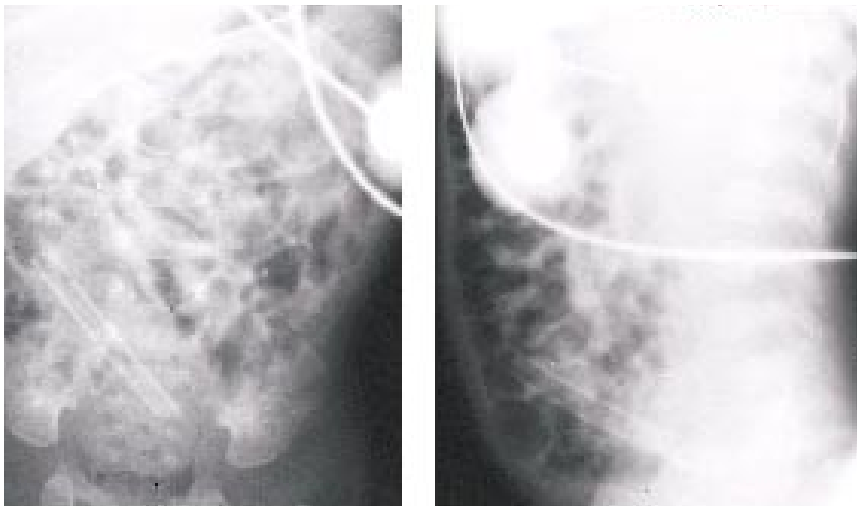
Abdominal radiographs of an infant who “swallowed a nasal CPAP tube.” The tube was recovered in the stool 11 days later. (Singleton, E.)
